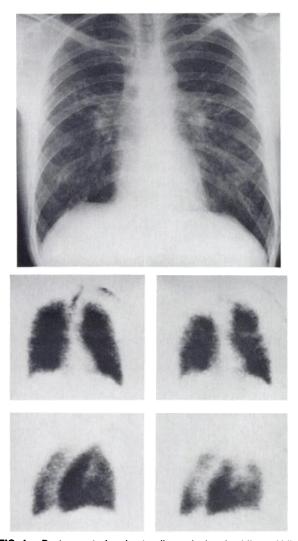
Postero-anterior chest radiograph showing bilateral hilar lymph-node enlargement and patchy fibrosis in upper and mid zones. Anterior and right posterior oblique views of ventilation scans (top) and similar views of perfusion scans (bottom) show small matched defects in left lung and an area of high ventilation/perfusion ratio at right apex.
